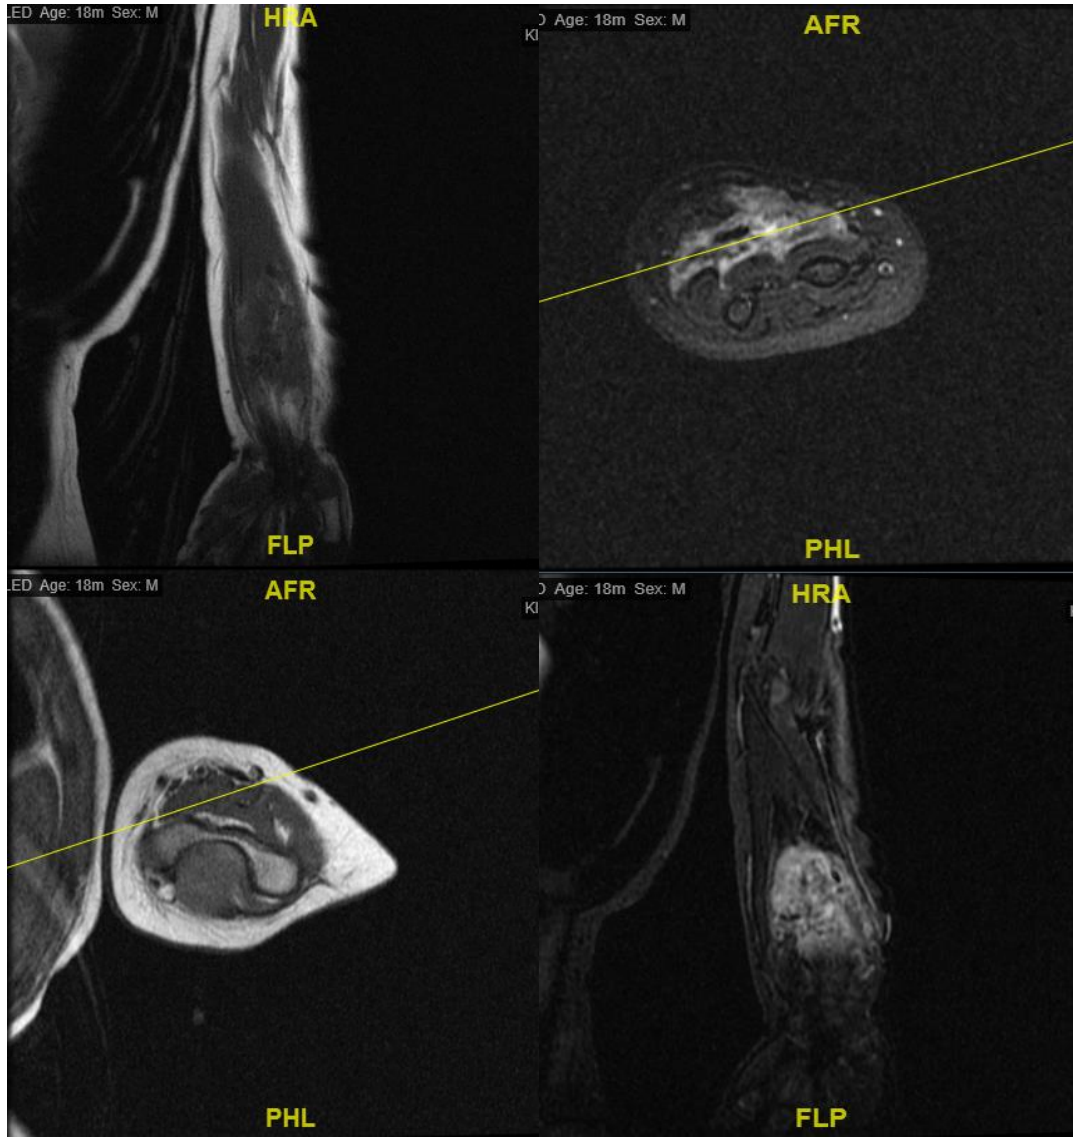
MRI forearm and wrist.
